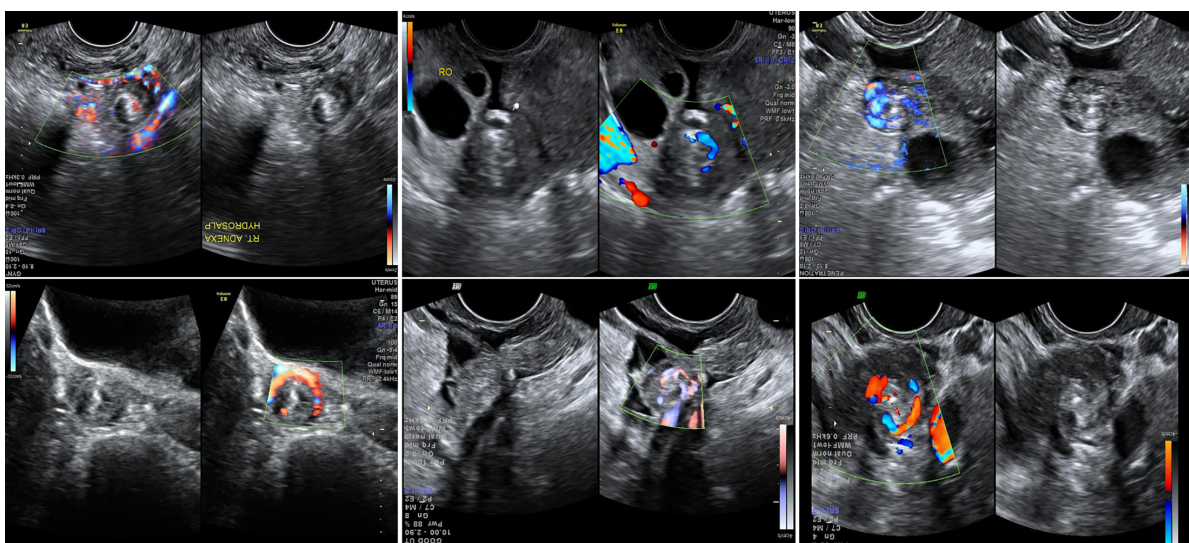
Ultrasound images of twisted adnexa manifesting whirlpool sign.
